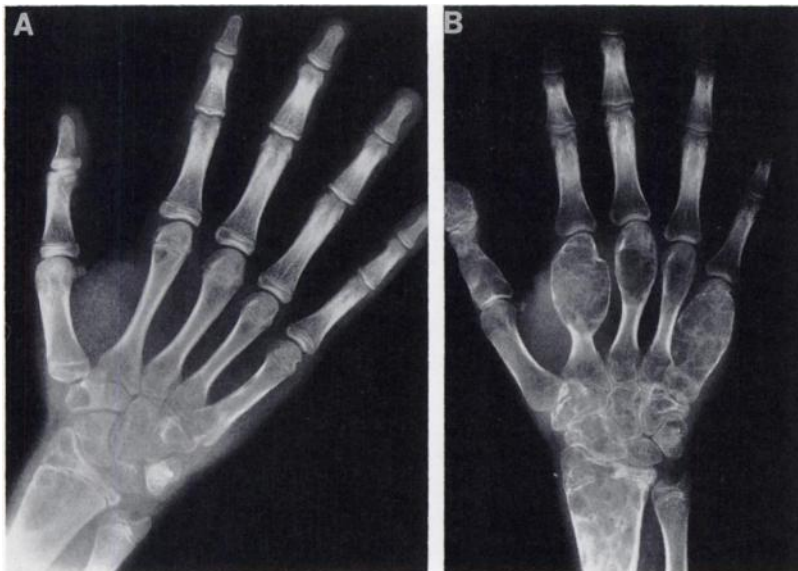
Radiographs of the left hand at presentation (A) and 13 mo later (B) demonstrating dramatic progression of expansile, lytic lesions.
